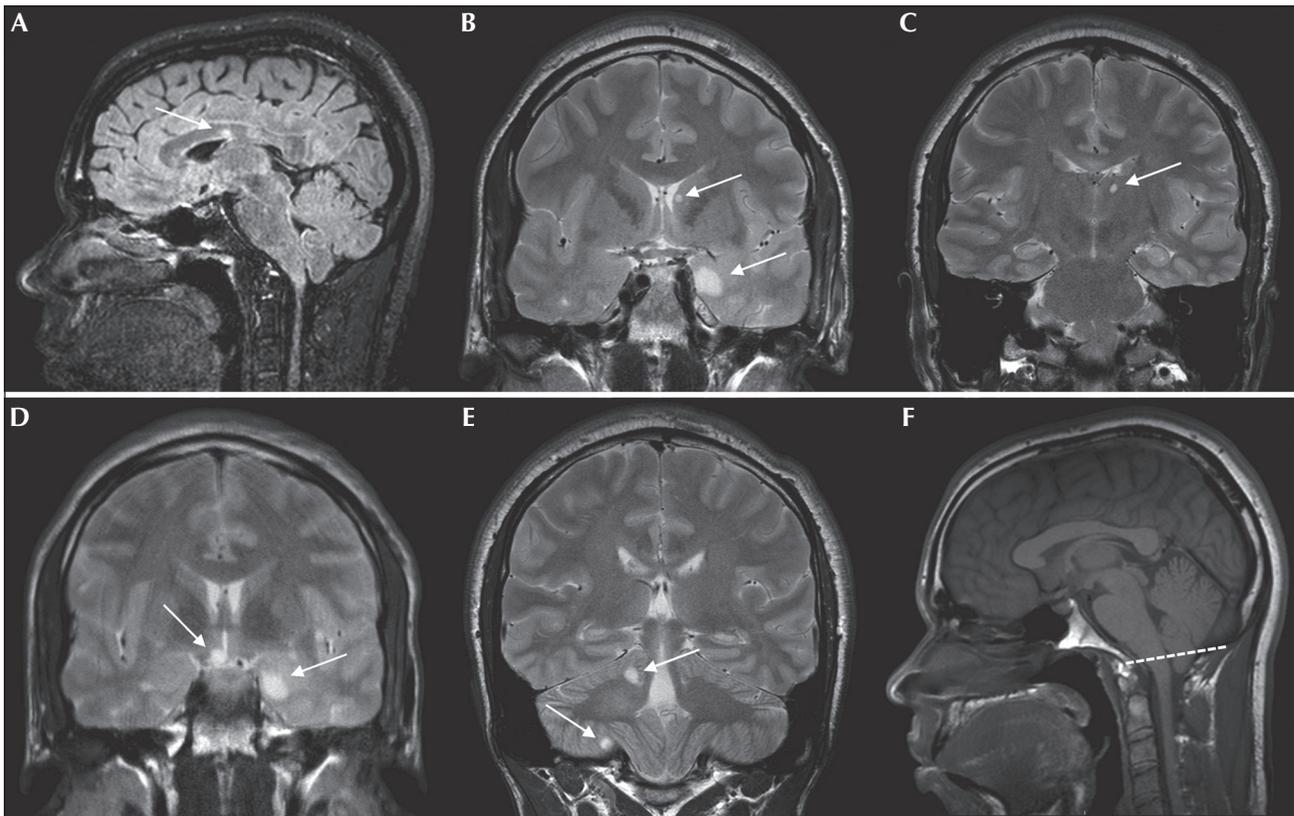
FLAIR MR image in the sagittal plane (A) and T2-weighted MR images in the coronal plane (B-E) show multiple DNETs in the corpus callosum (A), left caudate head (B), left medial temporal lobe (B, D), left thalamus (C), right hypothalamus (D), and right cerebellum (E).
